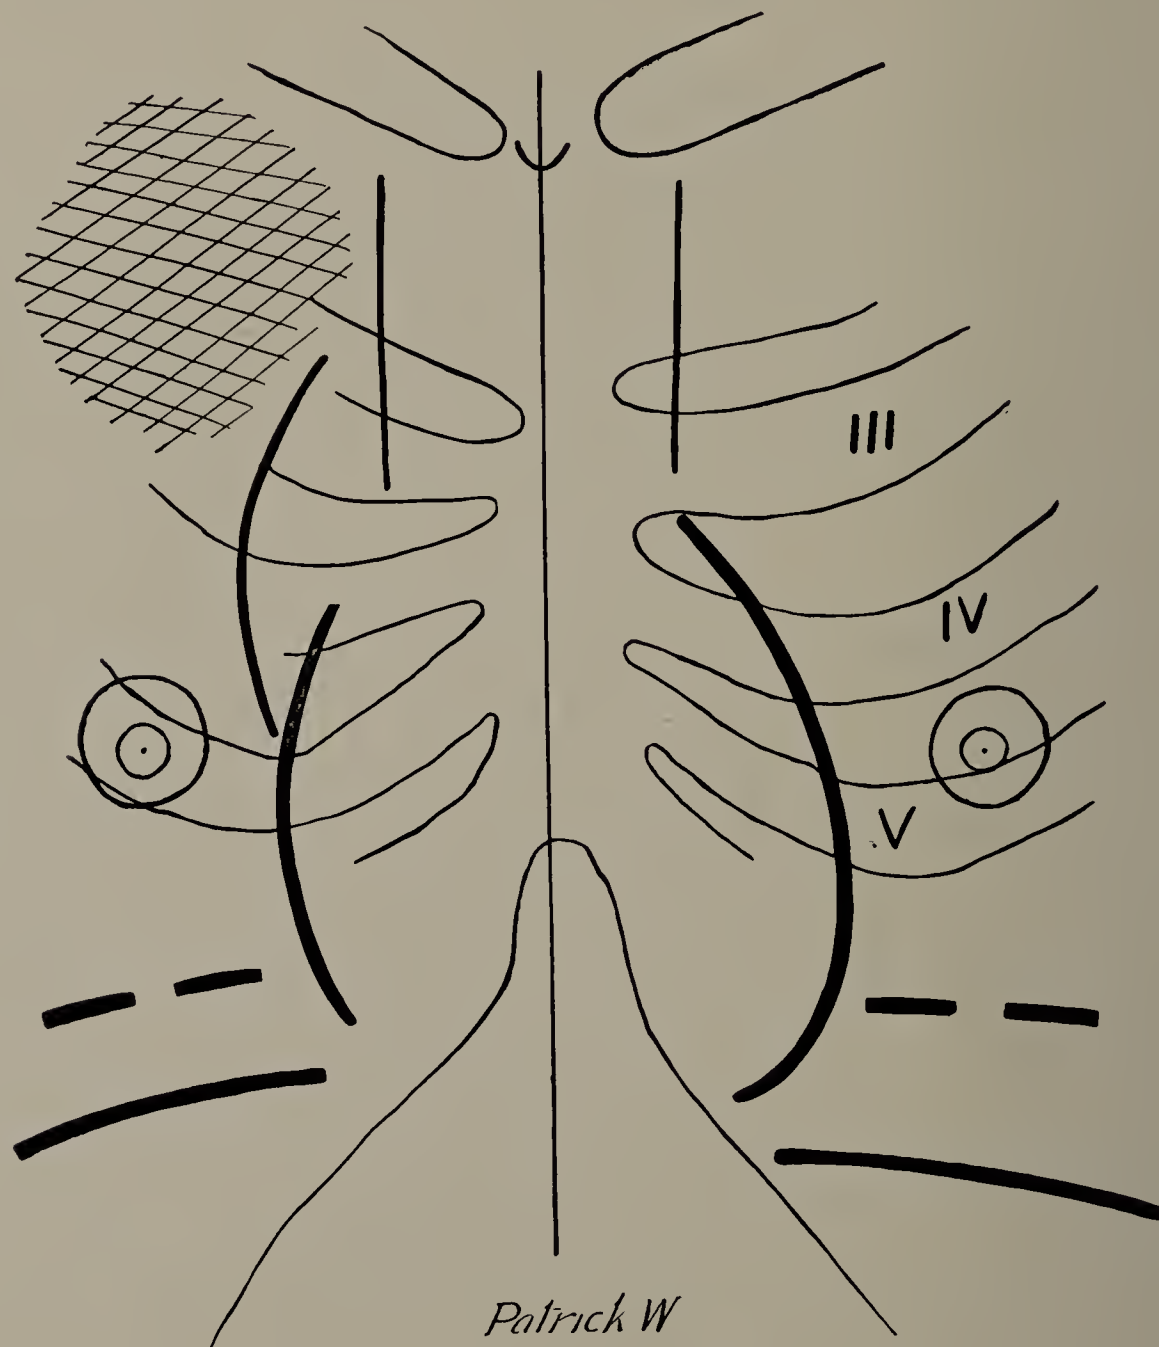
Patrick W. January 17, 1900. Emphysema. First X-ray tracing. Lungs brighter than normal except for darkened right apex. Diaphragm low down in chest; excursion limited on upper side. Long axis of heart nearly vertical, right side enlarged; little or no difference in position of heart between inspiration and expiration. (One-third life size.)
